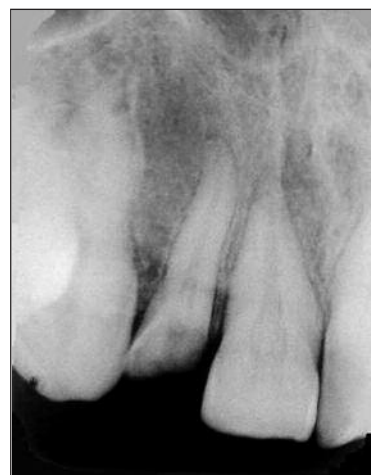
The radiographic image of the tooth after surgical extrusion.
